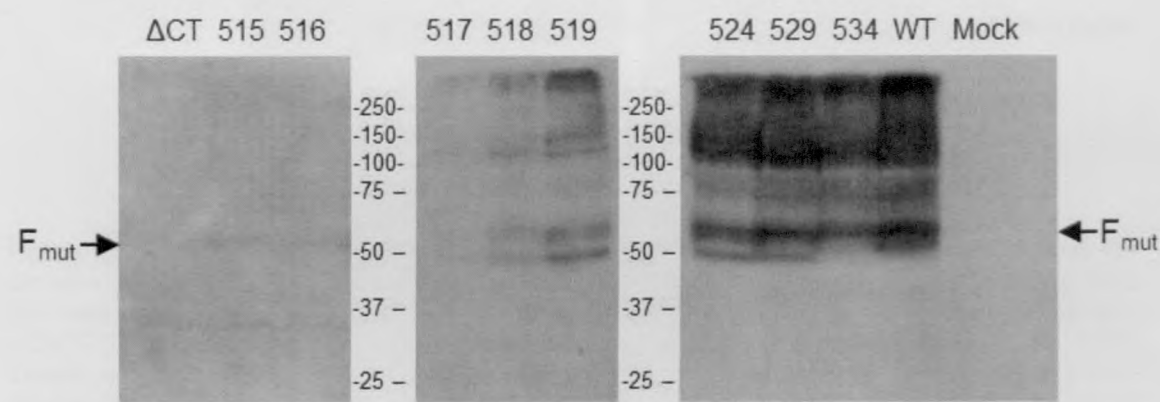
Western blot analysis of F cytoplasmic tail mutants which were probed with the anti-myc antibody. The numbers indicate the last amino acid residue of the mutant F proteins. Mock-mock transfected cells, WT-wild-type F_{WT} protein, ΔCT - $F_{\Delta CT}$ protein without cytoplasmic tail. The size range of the F mutants (F_{mut}) is approximately 54-58 kDa.
